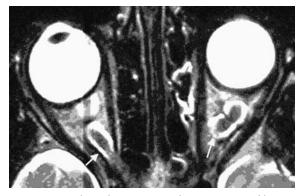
Bilateral optic nerve gliomas in neurofibromatosis type I. Axial T2-weighted MR image shows enlargement of both optic nerves (arrows), which presents as isointense to the gray matter and as surrounded by hyperintense cerebrospinal fluid.
